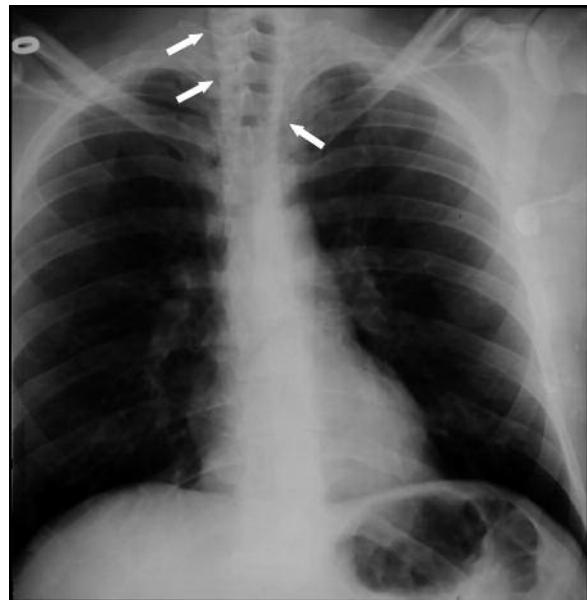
Chest X-ray on the day of accident.
